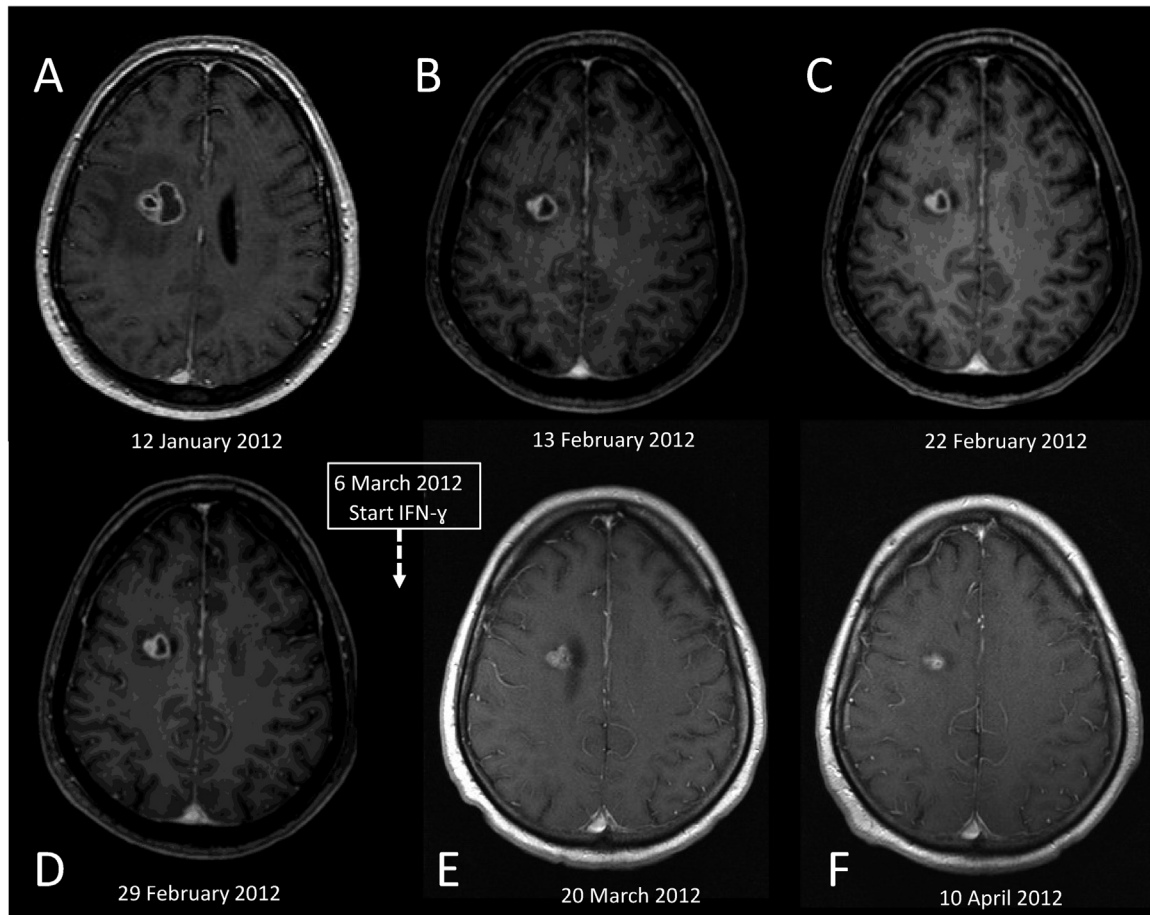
Studies of the largest right paraventricular brain lesion by magnetic resonance imaging (MRI). (A) T1-weighted contrast-enhanced hyperintense MRI image of the right brain lesion at admission on January 12, 2012 (size of lesion $25 \times 22 \times 20$ mm, with extensive surrounding oedema). (B) Culture-guided initial treatment with trimethoprim–sulfamethoxazole resulted in an initial decrease in size and reduction of the oedema (size of lesion $17 \times 15 \times 17$ mm). However, subsequent imaging showed little to no further reduction of the abscess: (C) size of lesion $15 \times 13 \times 19$ mm, (D) size of lesion: $16 \times 13 \times 19$ mm. Therefore, adjunctive immunotherapy with interferon-gamma treatment was initiated on March 6. (E) MRI performed 12 days later showed a decrease in the right paraventricular lesion (size of lesion $12 \times 13 \times 17$ mm). (F) Further improvements were observed on MRI 3 weeks later (size of lesion $12 \times 9 \times 12$ mm). All images are published with the permission of the patient's legal representative.
